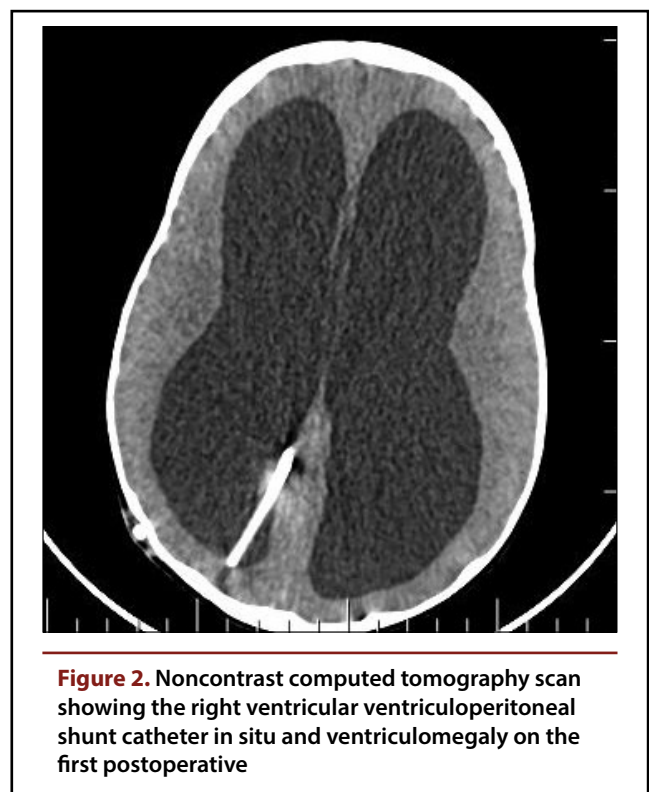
Noncontrast computed tomography scan showing the right ventricular ventriculoperitoneal shunt catheter in situ and ventriculomegaly on the first postoperative
